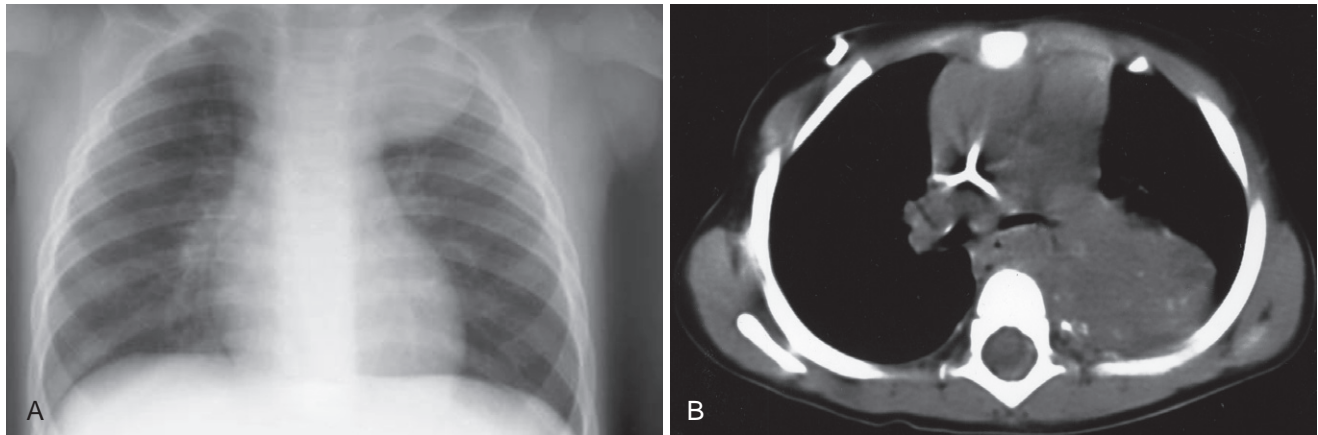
A, Plain chest radiograph shows the presence of a left upper thoracic tumor. B, Computed tomography scan documents a mass in the posterior mediastinum that contains calcium, suggestive of a neuroblastoma.
